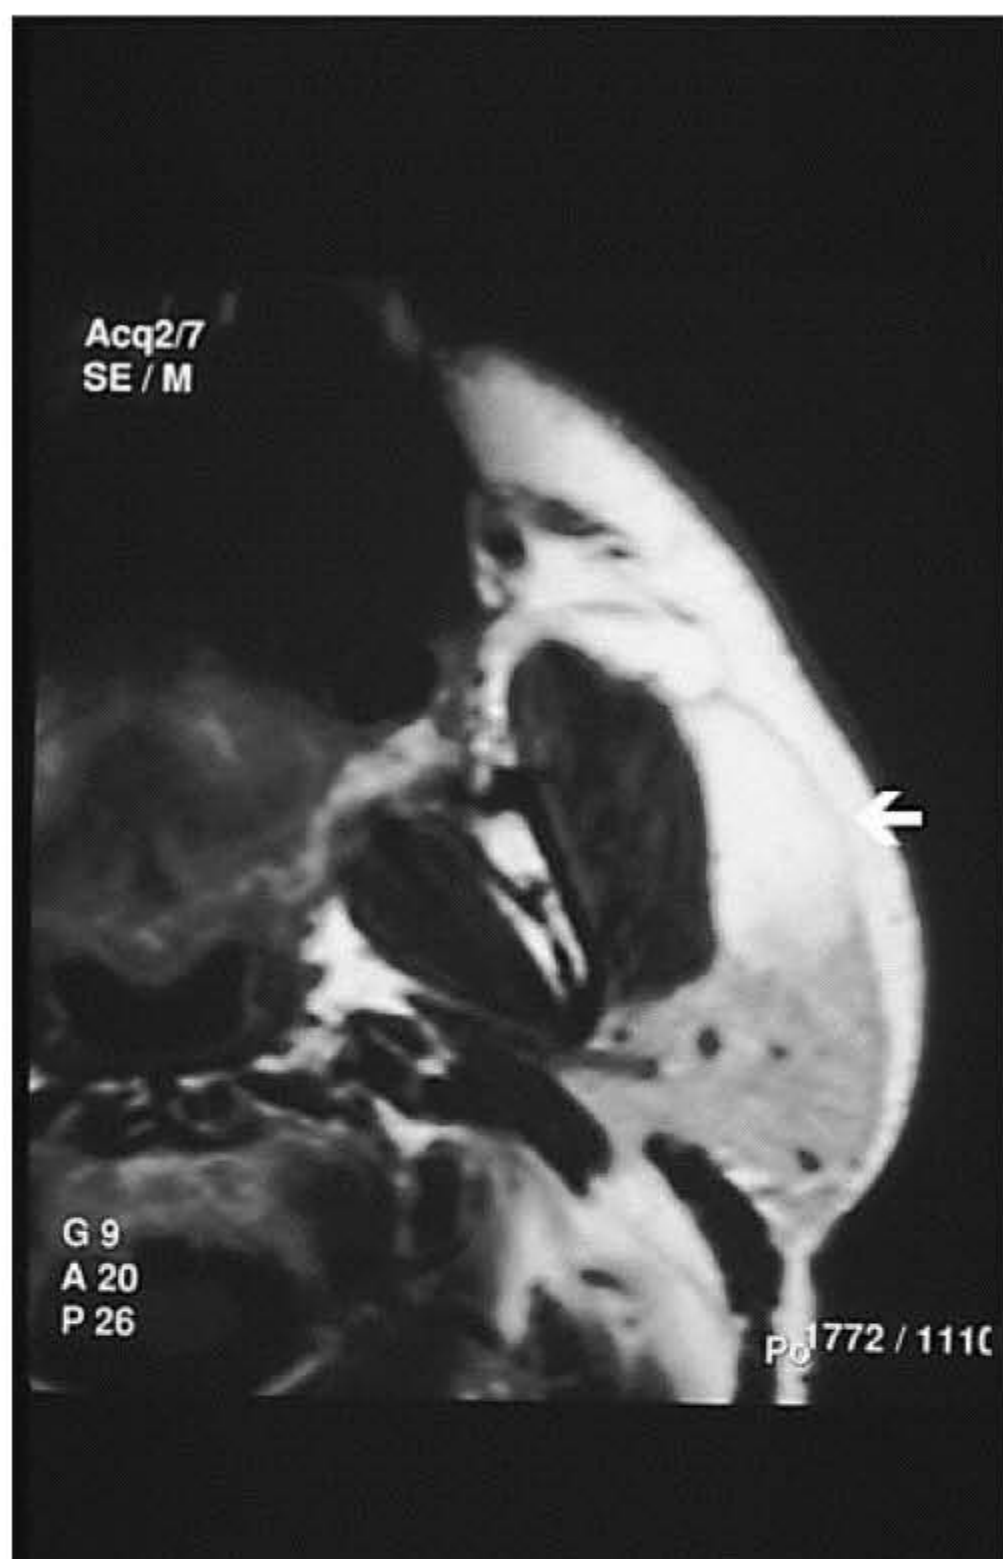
Lipoma (arrow) of the anterior part of the left parotid gland displacing the normal tissue on axial T1-weighted MRI.
